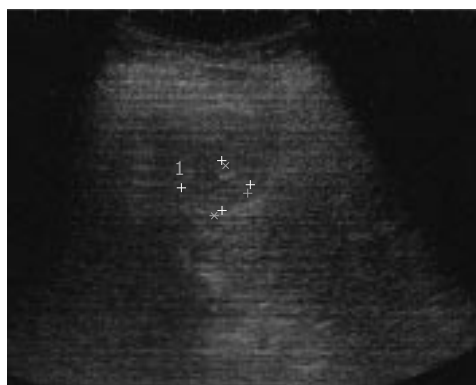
Ultrasound (US) image of a 20-mm hypoechoic nodule in segment 2 (S2).
